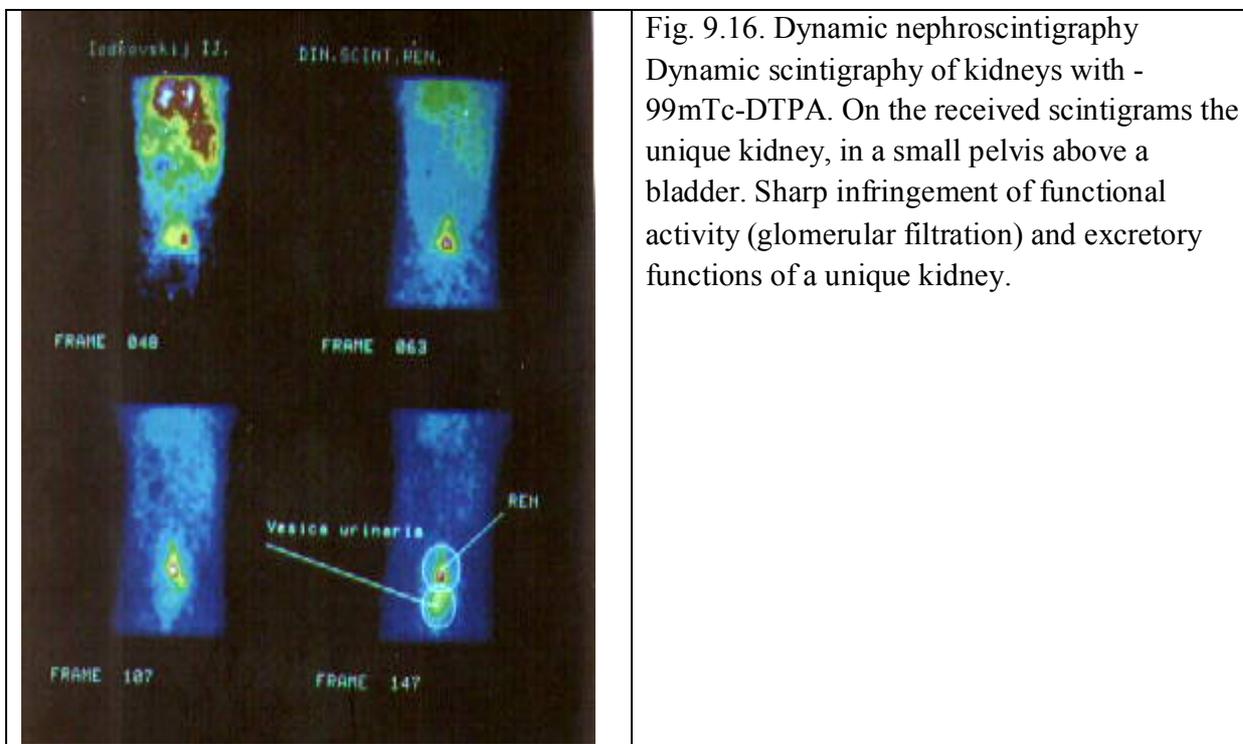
Dynamic nephroscintigraphy
